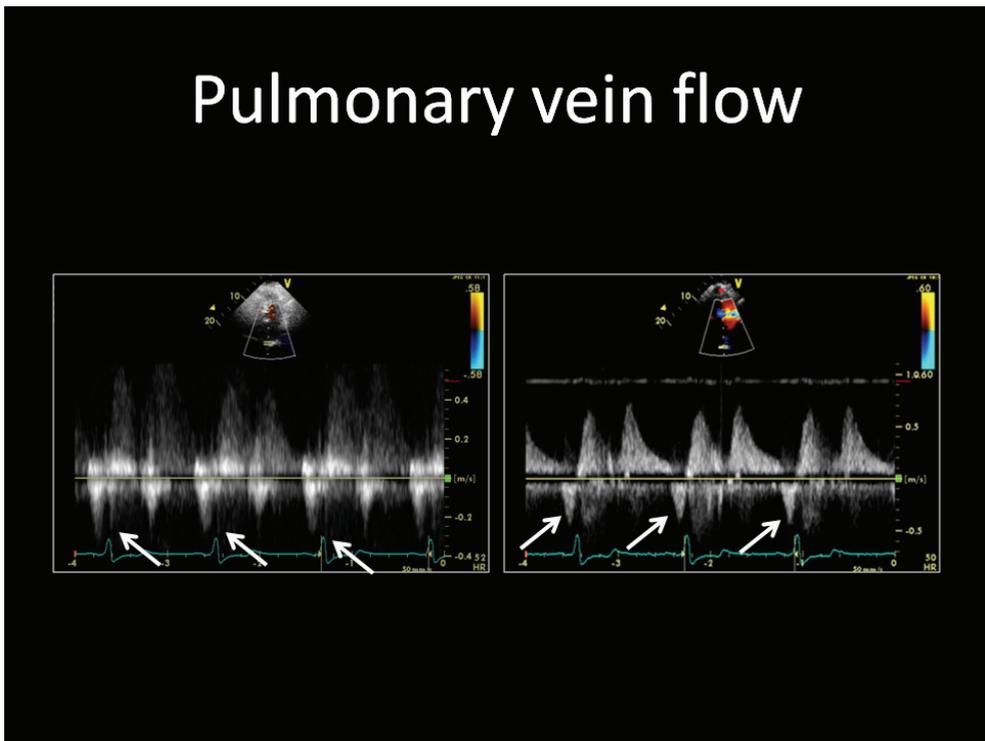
Pulsed wave spectral Doppler display of pulmonary venous flow. Left. Unenhanced image with adequate tracing of the systolic (S) and diastolic (D) waves, but difficult to discern the atrial reversal (AR) velocity (arrow). Right. Contrast enhanced image with optimal spectral Doppler tracing confirming the AR maximal velocity is abnormally increased at  $>40\text{cm/s}$  (arrow)
